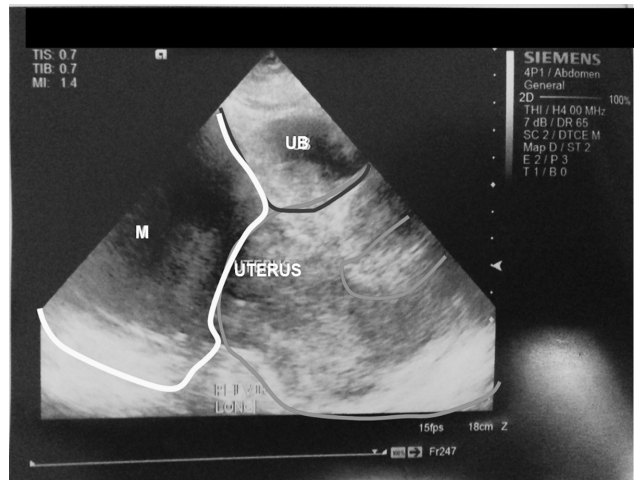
Ultrasound showing the anteverted uterus with thickened endometrium. There is a 14.85x11.43x16.95cm Pelvoabdominal cystic mass (M) with solid components closely related to the urinary bladder (UB) fundus of uterus.
